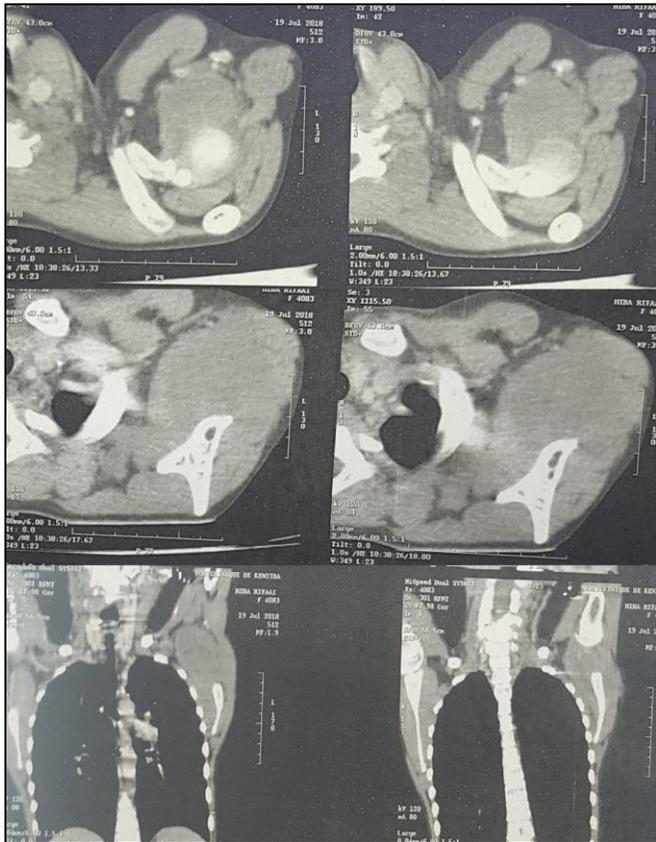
CT scan image of the left shoulder showing the process.
